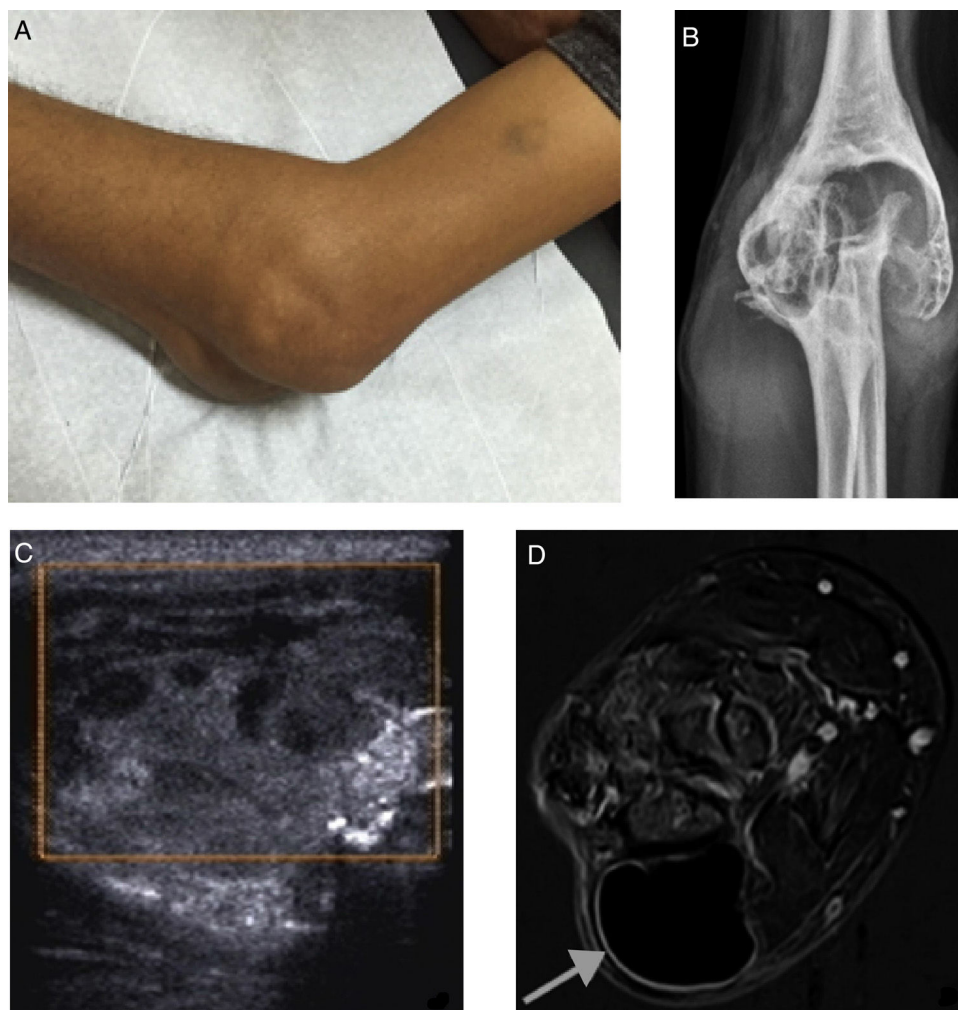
(A) Physical examination of the elbow demonstrating limited joint extension and deformity. (B) Radiography with notable bone deformity, in particular the distal humerus. (C) Ultrasonography demonstrating heterogeneous, ill defined, oval deformity with adjacent bone irregularity without vascularization according to a Doppler study. (D) Contrast T1 FAT SAT MRI with subtraction shows morphostructural deformity of elbow joint, with extensive deposition of low signal material in the synovium (hemosiderin) and extra-osseous hemophilic pseudotumor measuring 4.9 × 3.5 × 3.6 cm (gray arrow).
